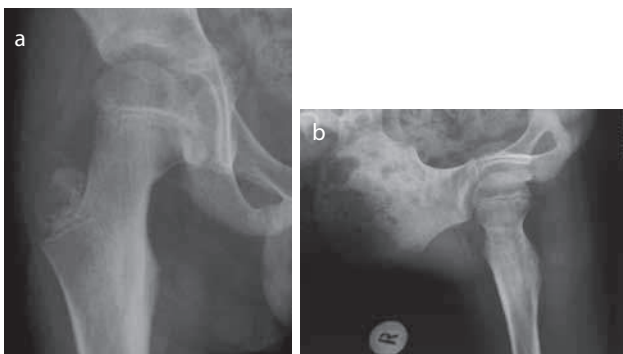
(a) Anteroposterior and (b) frog-lateral X-rays: A sclerotic lesion near the lesser trochanter with a suspicion of a small lucency (nidus).
